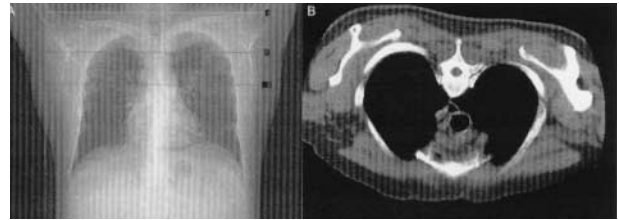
Plain radiograph is used to demonstrate the level of a cross-sectional image. A. Chest radiograph demonstrating highest and lowest levels of CT images taken and the level of CT image currently being examined; B. Cross-sectional CT image.
